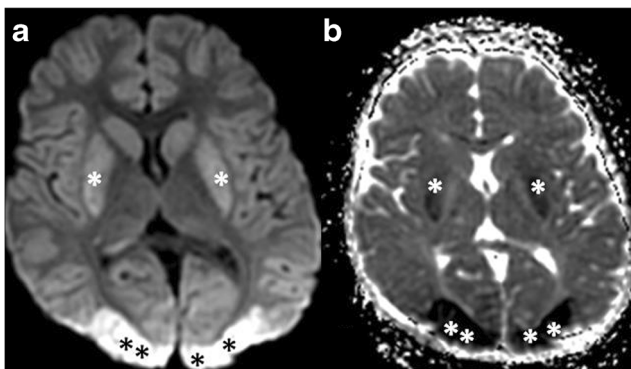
Methadone intoxication in a 4-year-old patient. Cytotoxic edema is observed in the posterior putamen (*single asterisks*) and occipital (*double asterisks*) regions on DWI (a) and ADC map (b) in a 6-month-old female
